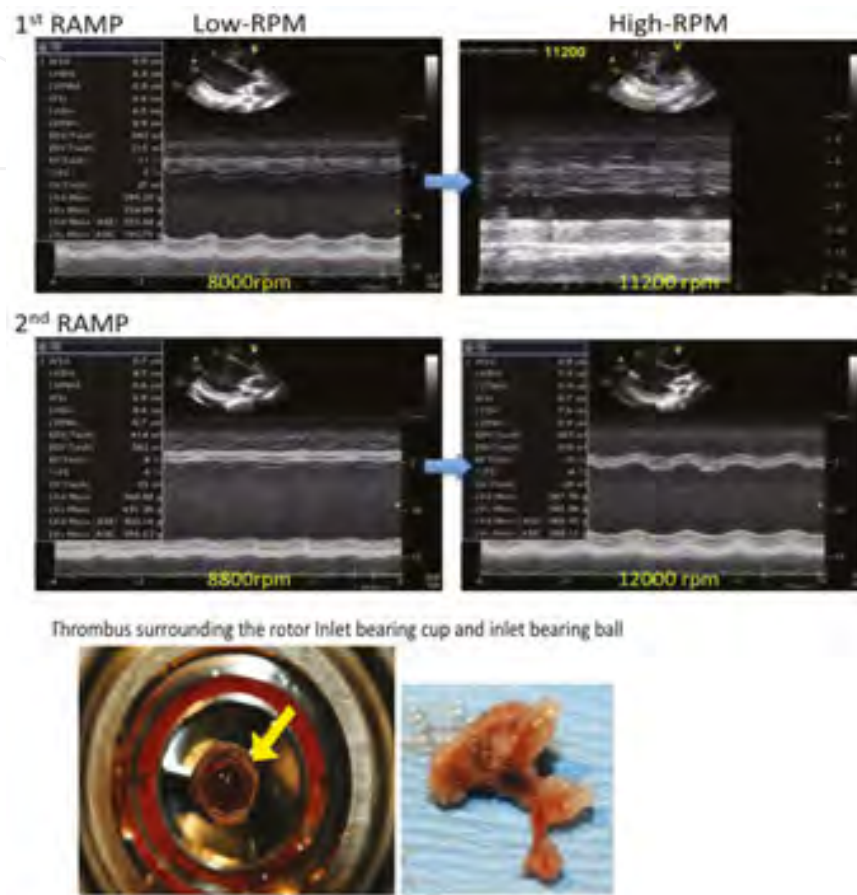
A representative case with device thrombosis was detected by a ramp echocardiography device (quoted from Ref. [24]). A case of a 29-year-old woman undergoing HeartMate II LVAD implantation; serial ramp studies were used to diagnose intradevice thrombus after device implantation. The first ramp study on postoperative day (POD) 26 revealed an adequate reduction in ventricular size according to the increase in LVAD. The patient was discharged home and received routine anticoagulation maintenance therapy. However, a second ramp test was performed on POD 56 due to increased lactate dehydrogenase and brain natriuretic peptide levels and showed a marked increase in the LV chamber size without an adequate response to the LVAD speed changes. Given the suspicion for partial pump thrombosis, the patient was immediately hospitalized and received intravenous heparin infusion. The patient eventually underwent cardiac transplant successfully, and the partial clot was found inside of the pump (lower panel).
